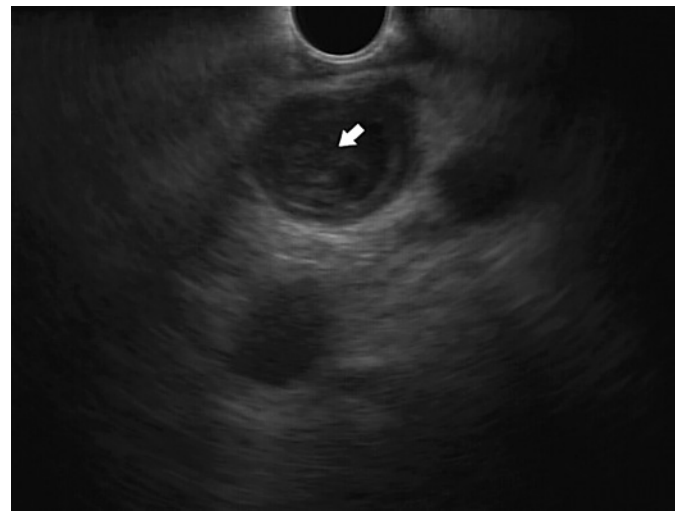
Ultrasonographic investigation from the stomach revealing direct communication between the cystic lesion and a dilated MPD (12 mm) with stratified and thick walls that is filled with dense material and mucus plugs (arrow).
